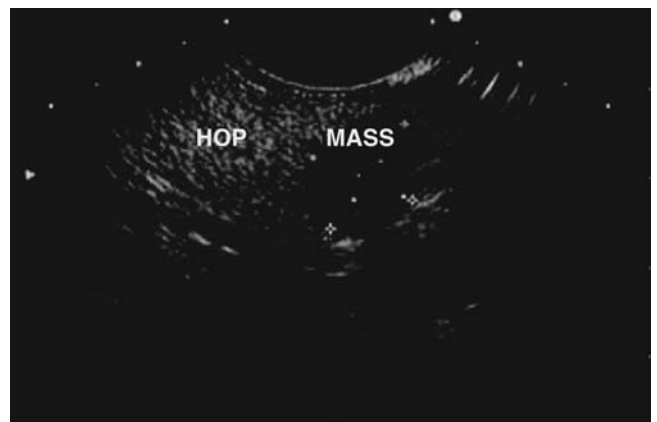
Transgastric endoscopic ultrasound (EUS) in a patient with an insulinoma in the neck of the pancreas. The mass (MASS) seen adjacent to the head of the pancreas (HOP) appears hypoechoic relative to the surrounding pancreatic tissue. (Used, with permission, from Richard W. Goodgame, MD, University of Texas Medical Branch, Galveston, TX.)
